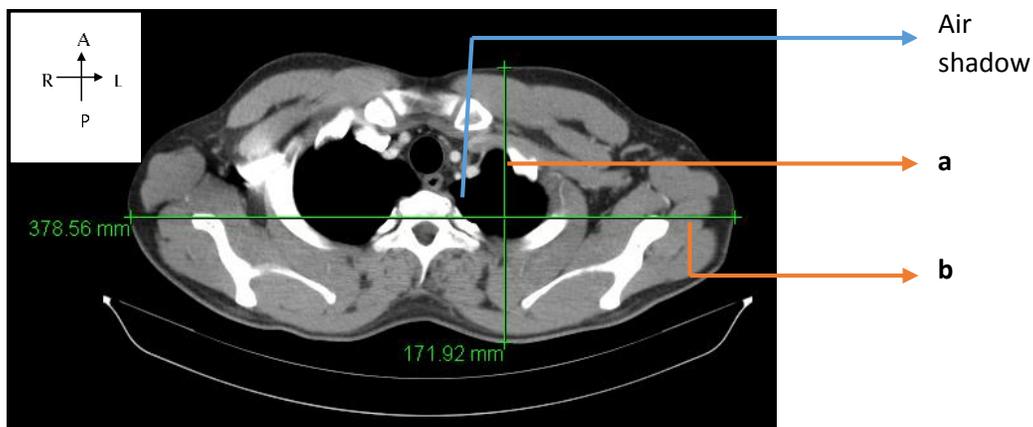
CT Thorax- Tomographic Image Measurements- At Apex of Lung (Level T1)
